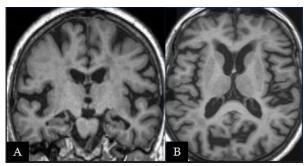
Cerebral MRI in an 84-year-old female patient presenting with dementia with Lewy bodies shows frontal atrophy on the coronal (A) and axial (B) FLAIR T2 sequences.
